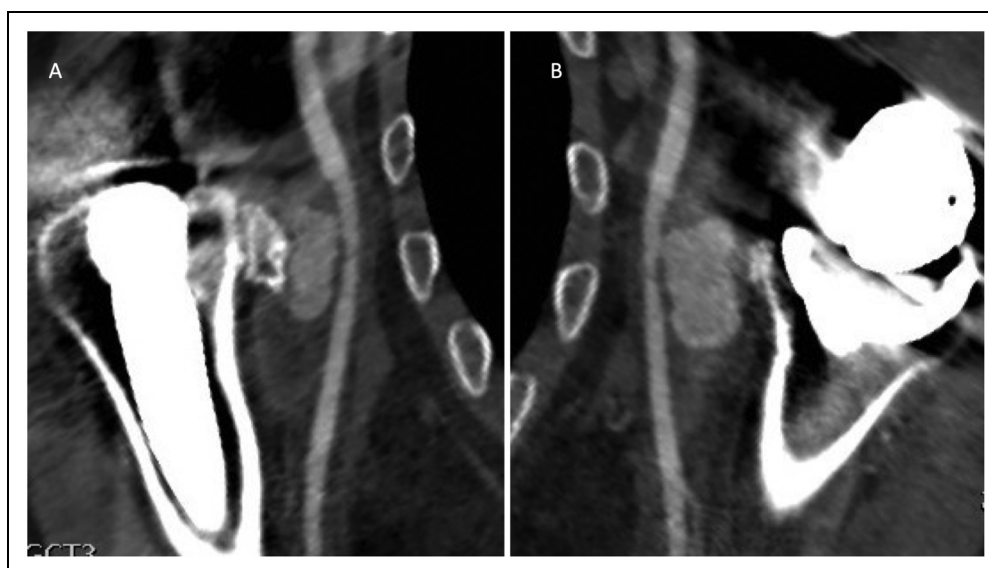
A-B. Two CT angiogram cuts presenting pseudoaneurysm next to proximal humeral osteophyte.
